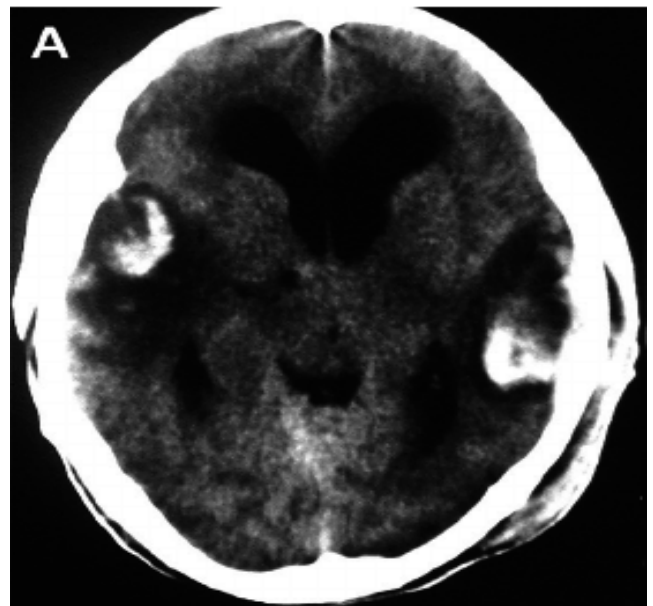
CT brain showing- bilateral temporal contusion.
